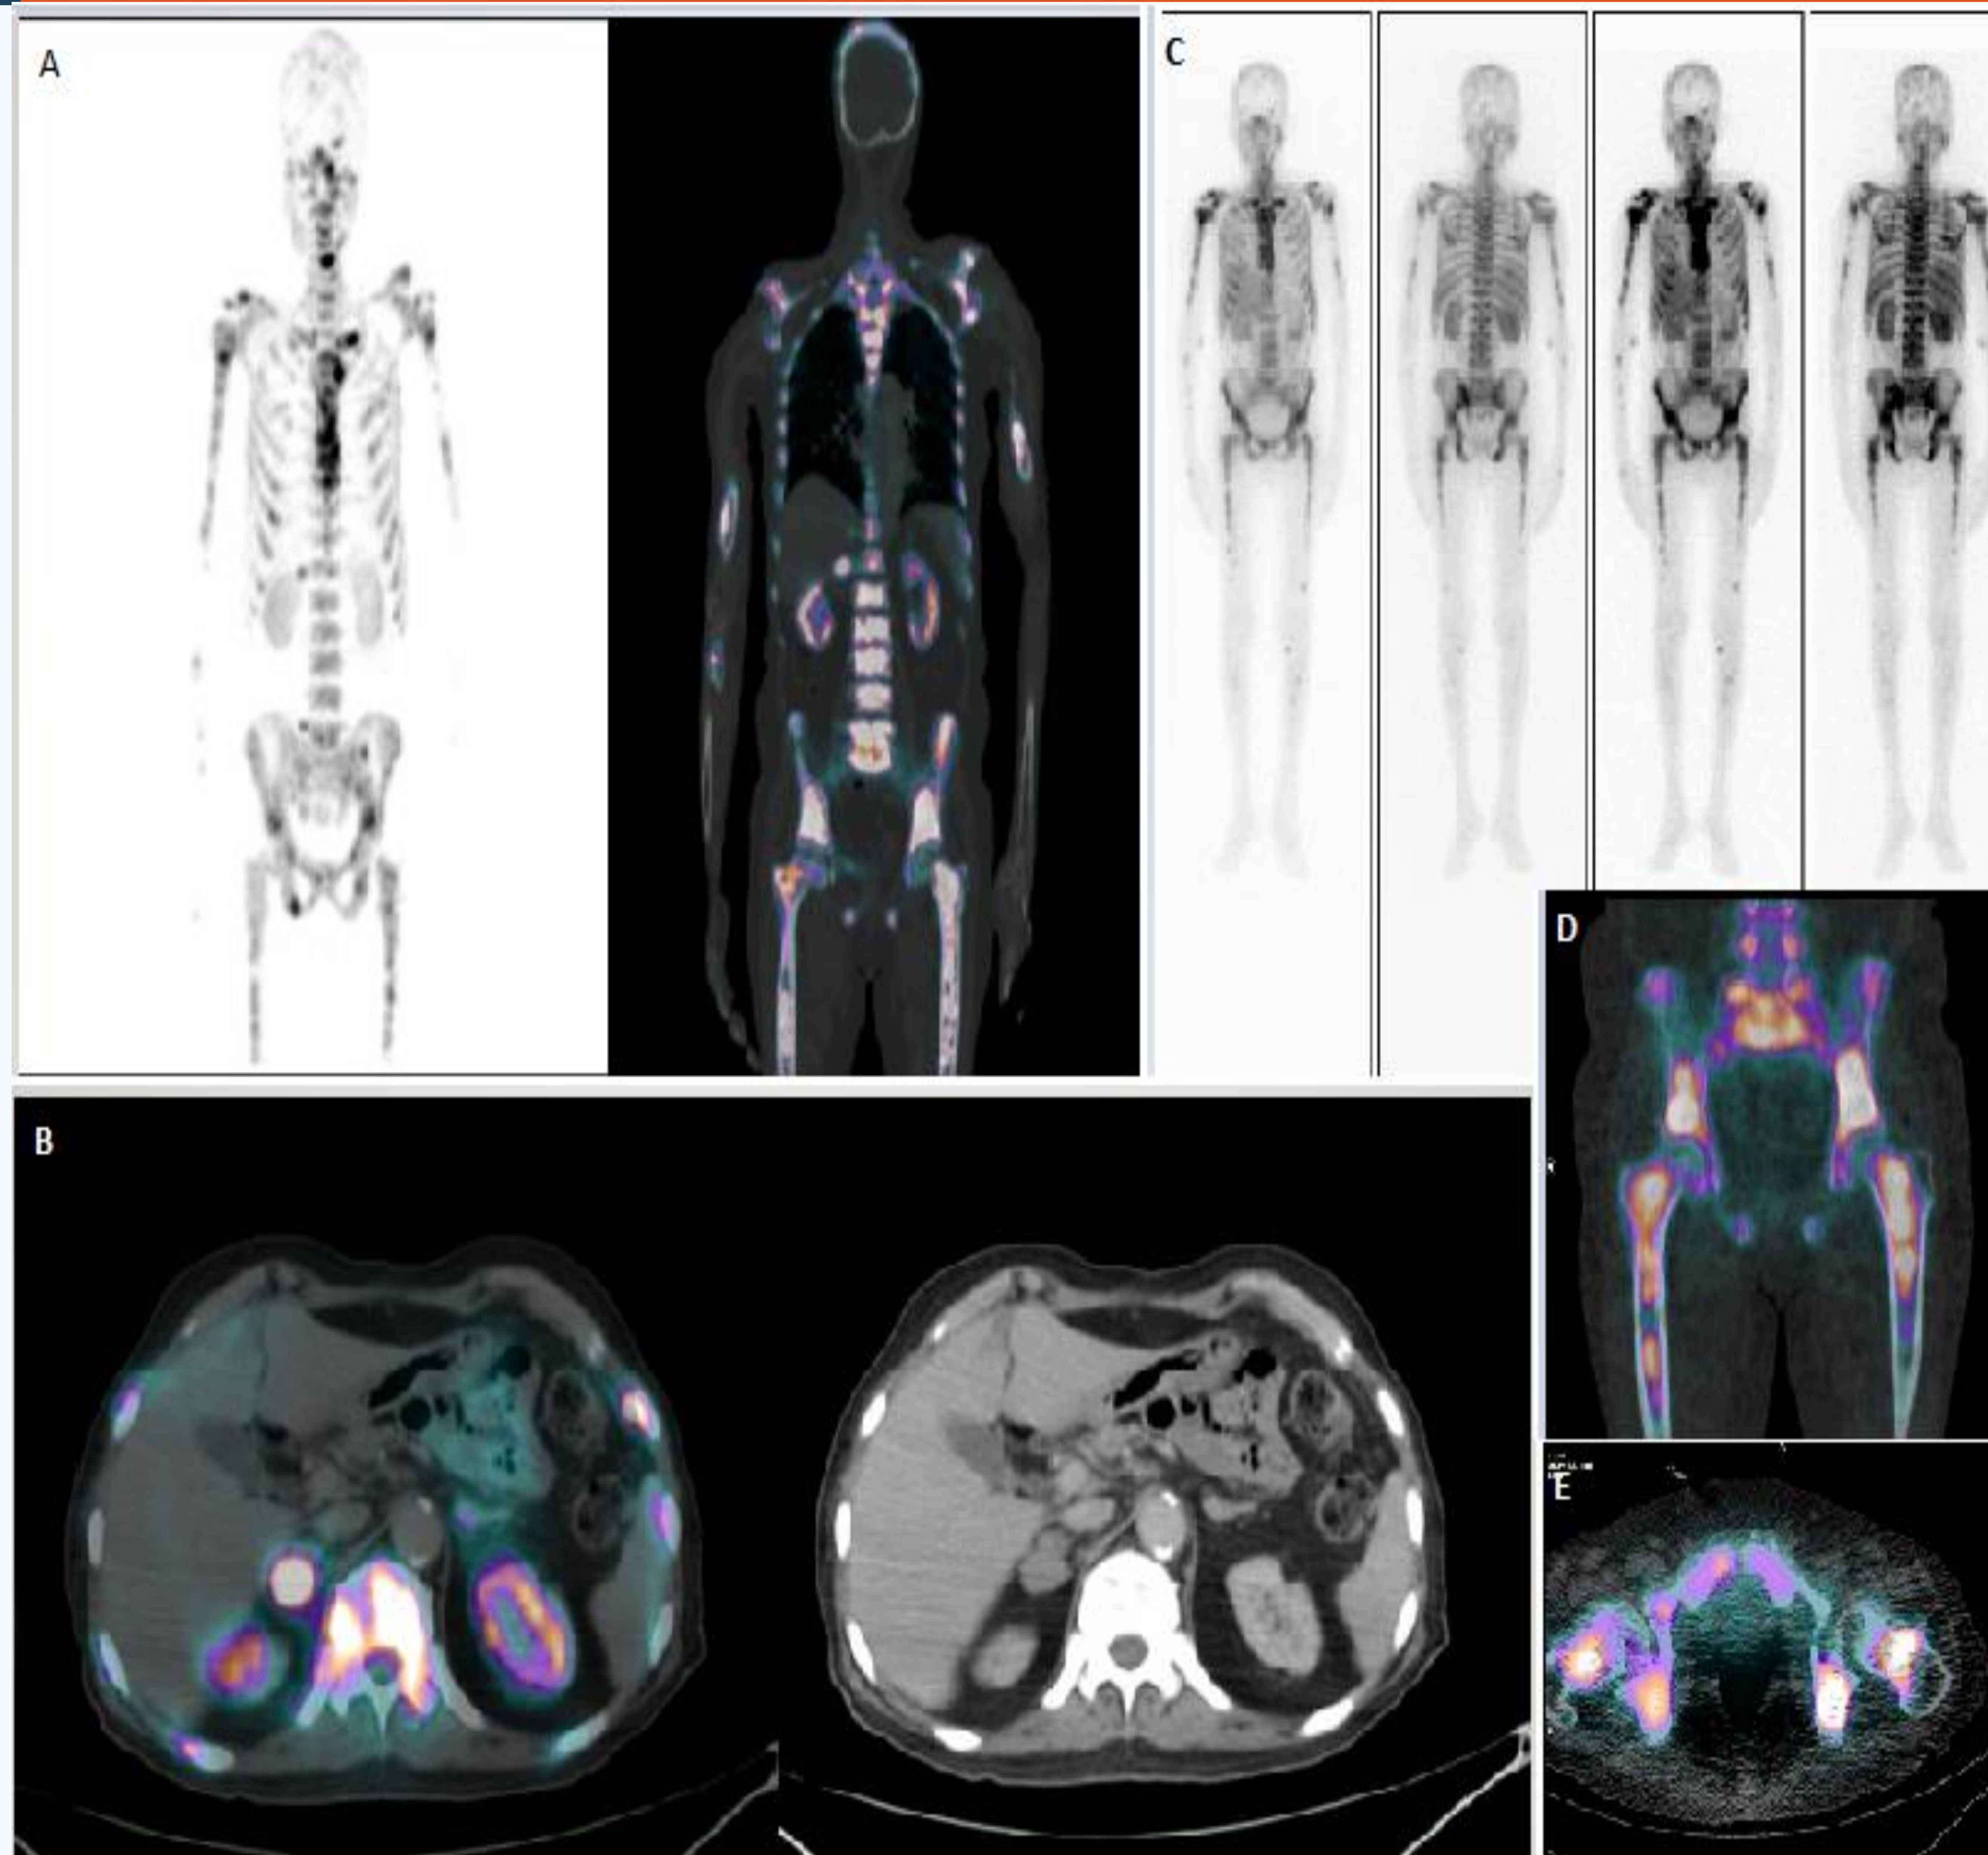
A. Ga-68 PSMA PET MIP and fused PET-CT coronal images showing extensive skeletal and bone marrow involvement in axial and appendicular skeleton. Fig: B. Axial views showing nodal metastasis in right suprarenal region. Fig: C. Tc-99m PSMA whole body planar images anterior and posterior views, Fig: D. and Fig: E. limited SPECT-CT coronal and axial views showing similar skeletal and bone marrow findings except for the nodal lesion.
